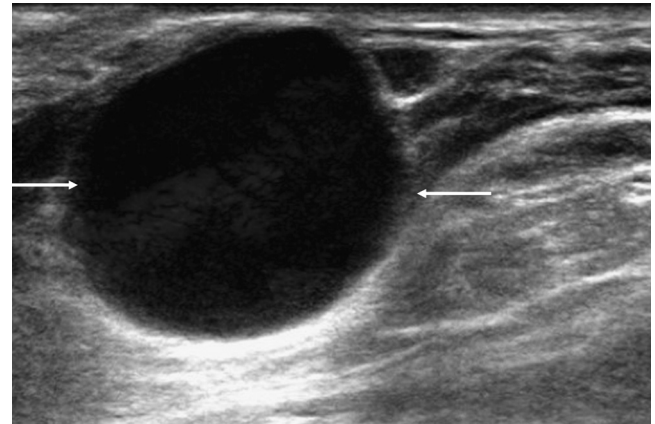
A spermatic cord cyst. The sonography of the right groin, revealing a discrete anechoic cyst (arrows) along the spermatic cord in the inguinal canal.
